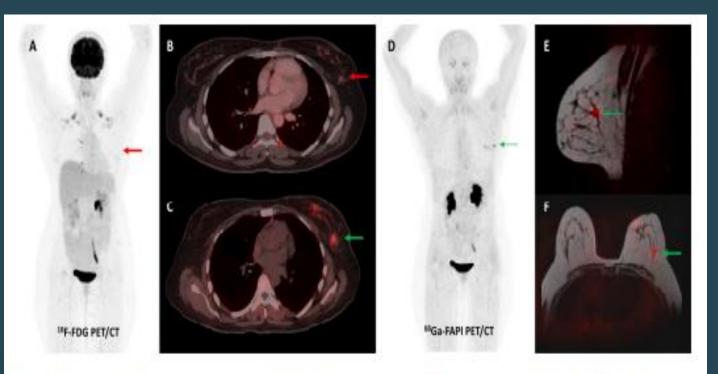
Forty-four-year-old woman, a known case of epithelial ovarian carcinoma post hysterectomy and bilateral salpingo-oophorectomy, underwent FDG and [68Ga]Ga-FAPI-04 PET/CT for restaging. FAPI tracer avid ((C,D)—green arrows) and non-FDG avid ((A,B)—red arrows) ill-defined soft tissue density nodule (~1 × 0.8 cm) was noted in the upper outer quadrant of the left breast, which was corroborated on the fused PET-MR mammogram images ((E,F)—green arrows). Subsequently, an ultrasound-guided left breast biopsy was performed which showed invasive lobular carcinoma with ER/PR positive and HER2 negative receptor status.
